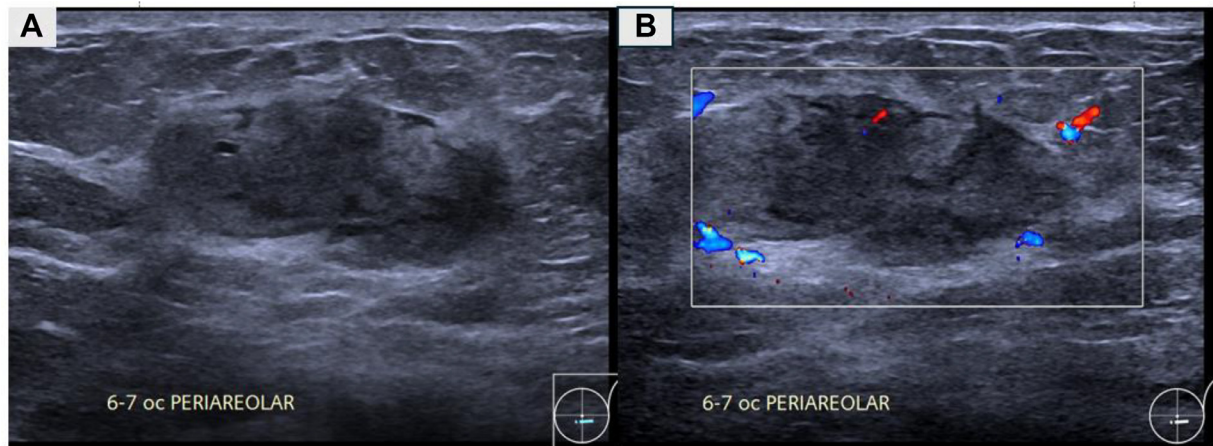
A well-circumscribed heterogeneous hypoechoic lesion parallel to the skin at 6-7 o'clock periareolar region (A). Minimal vascularity at the periphery of the lesion on color Doppler (B).
